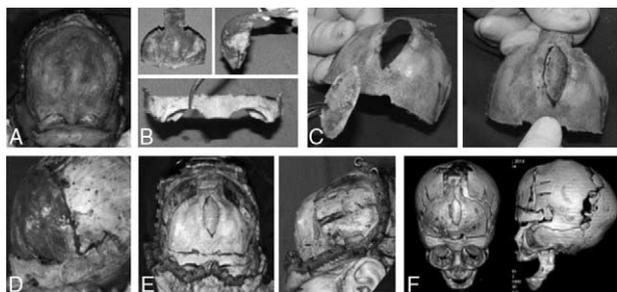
Surgical technique. (A) Metopic suture synostosis. (B) Frontal bone and supraorbital bar grafts segments. (C) Frontal cranioplasty: metopic ridge fusiform bone fragment after osteotomy and edge milling and its placement on the posterior wall of the frontal bone. (D) Tongue in groove self-stabilizing supraorbital advancement. (E) Frontal and lateral views after bone fragments were fixed with an absorbable material. (F) Postoperative computed tomography.
